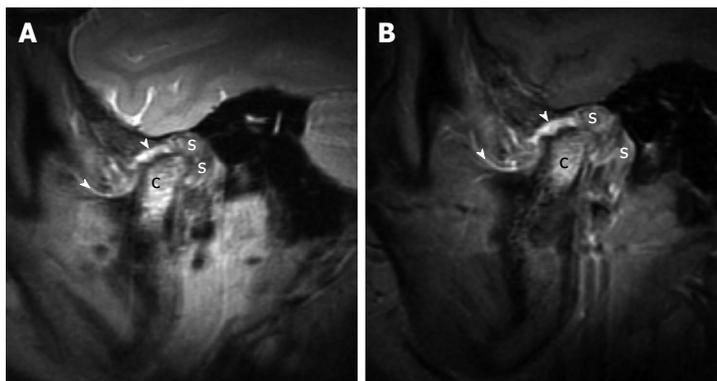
Juvenile idiopathic arthritis. A: Sagittal proton density weighted magnetic resonance imaging (MRI) in the closed mouth position demonstrates increased signal at the mandibular condyle (the letter, c), extensive thickening of the synovium (the letter, s) in the retrodiscal regions. It can be noted that the thickening and increased signal of the synovium at other places (arrowheads); B: Sagittal fat suppressed post contrast T1 weighted MRI in the closed mouth position demonstrates enhancement of signal at the mandibular condyle (the letter, c), enhancement and extensive thickening of the synovium (the letter, s) in the retrodiscal regions. There is thickening and enhancement of the synovium at other places (arrowheads).
